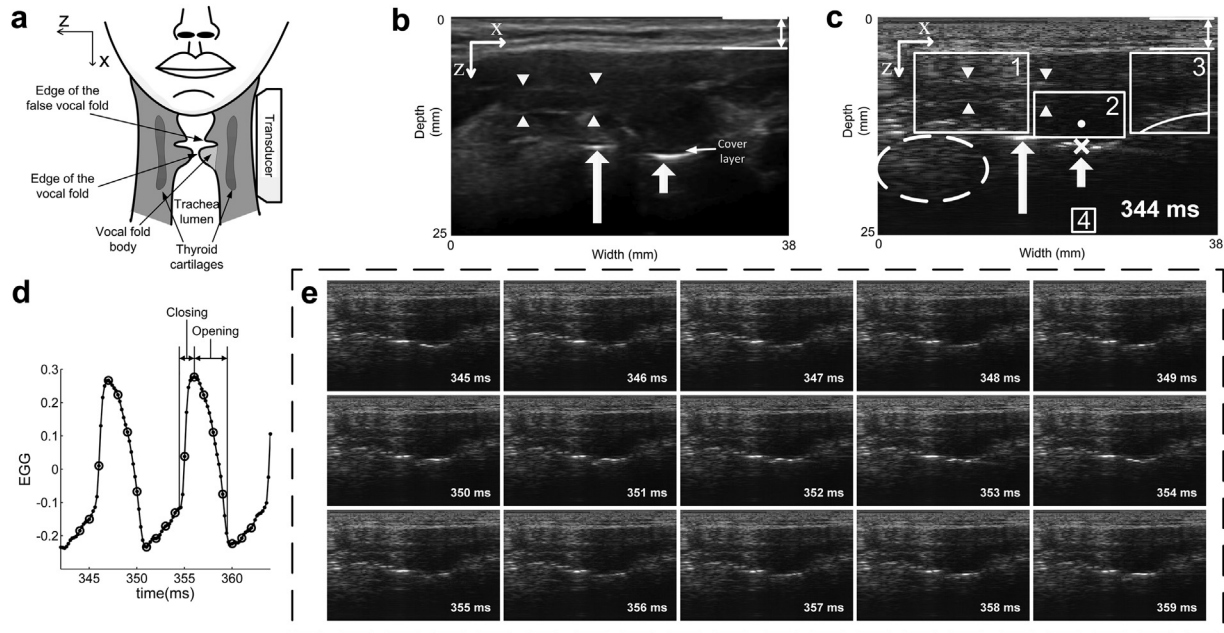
Setup for imaging of the larynx and the acquired ultrasonic images. (a) Relative position of the ultrasound transducer and laryngeal structures. The horizontal and vertical directions are referenced to the subject. The horizontal direction is indicated by the z-axis. The vertical direction is indicated by the x-axis. (b) Frame of conventional B-mode ultrasonic images of the region under investigation. The location of the hypo-echoic cover layer is pointed out in the image. (c) Identification of the laryngeal structures in the ultrafast plane wave ultrasonic image. Four arrowheads in (b) and (c) indicate the location of the thyroid cartilage. The long arrow and short arrow point to the edges of the false vocal fold and the vocal fold, respectively. The double-headed arrow points to the neck skin. Reverberation artifacts in the trachea lumen are indicated by the dashed ellipse. The supraglottic region, the vocal fold body, the subglottic region and the region where the noise floor is estimated are indicated by white rectangles numbered 1, 2, 3 and 4 respectively in (c). The curve near the bottom of the region 3 indicates the location of the subglottic mucosal surface. The white cross mark in (c) is at the vocal fold edge. The white round dot right above the cross mark is in the vocal fold body. (d) Short segment of electroglottography (EGG). (e) Simultaneously acquired ultrasonic images (decimated to 1000 frames/s). The closing and opening phases are pointed out in (d). The black dots in (d) indicate the moment of acquisition of ultrasonic images, and the black circles indicate the moment of acquisition of the images in (e).
